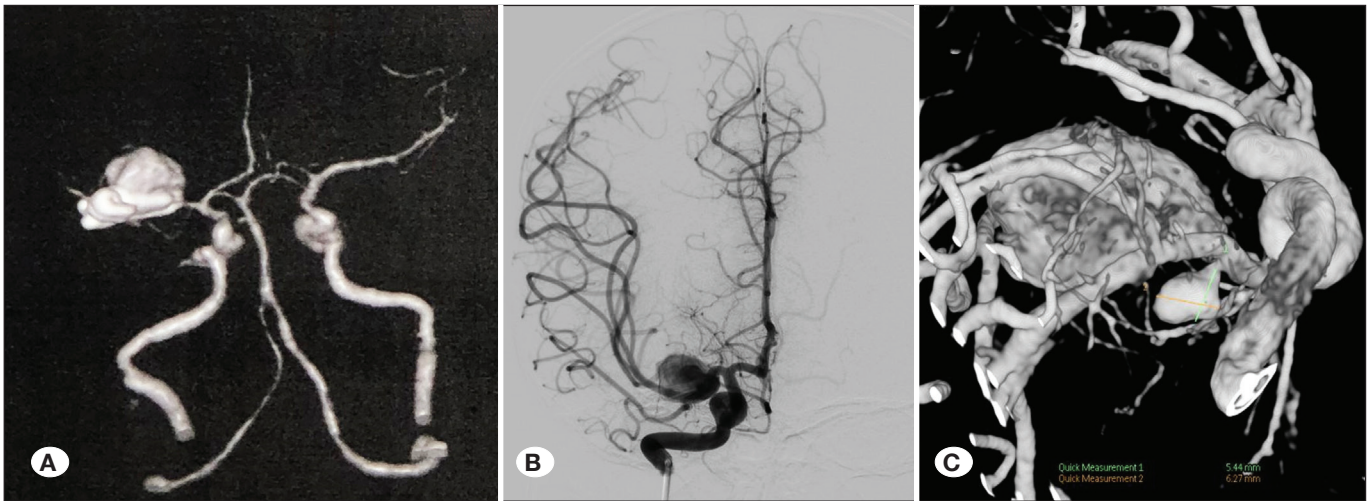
Right internal carotid angiogram 3 months after surgery show a recurrent MCA aneurysm. A) Computed tomography angiography. B) Digital subtraction angiography. C) A reconstructed 3D DSA confirms a new aneurysm has developed near the recurrent aneurysm.
